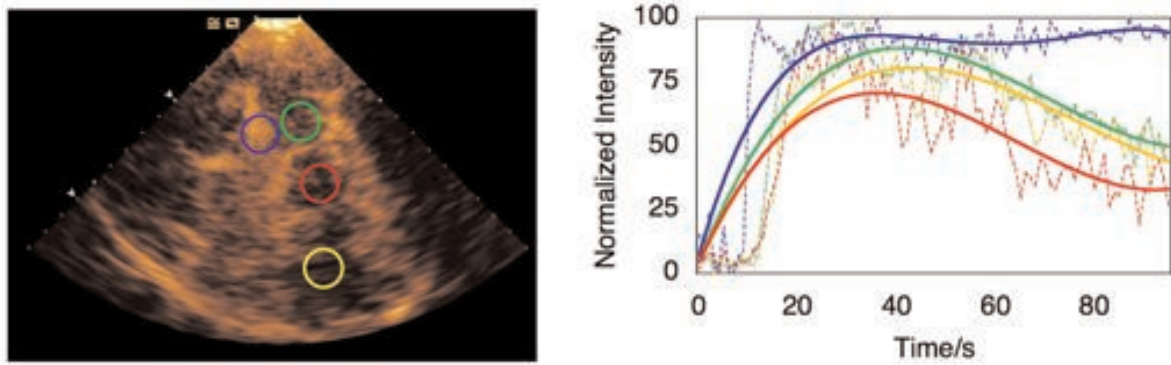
Contrast-enhanced transcranial B-mode sonography in the axial diencephalic plane in a 23 year old healthy volunteer after intravenous application of the contrast agent SonoVue (left), and the time intensity curves in the ipsi- and contralateral MCA territories (right), showing the mean intensity values and a good distribution of the contrast agent after 15 seconds - not only ipsilaterally, but also on the contralateral side. Triggered registration with a pulsing interval of 1000 ms ($MI = 1.1$). Raw data is shown in dotted lines. The trend lines more clearly depict the perfusion dynamics (the region of interest marked with a blue circle and a blue line shows higher intensity values than those measured in the neighbouring regions, as it was placed in the area of the left middle cerebral artery). *With permission: Bartels E, Henning S, Wellmer A et al (2005) Evaluation of cerebral perfusion deficit in stroke patients using new transcranial contrast imaging CPS™ technology. Preliminary results. Ultraschall in Med 26:478-486, Georg Thieme Verlag*
